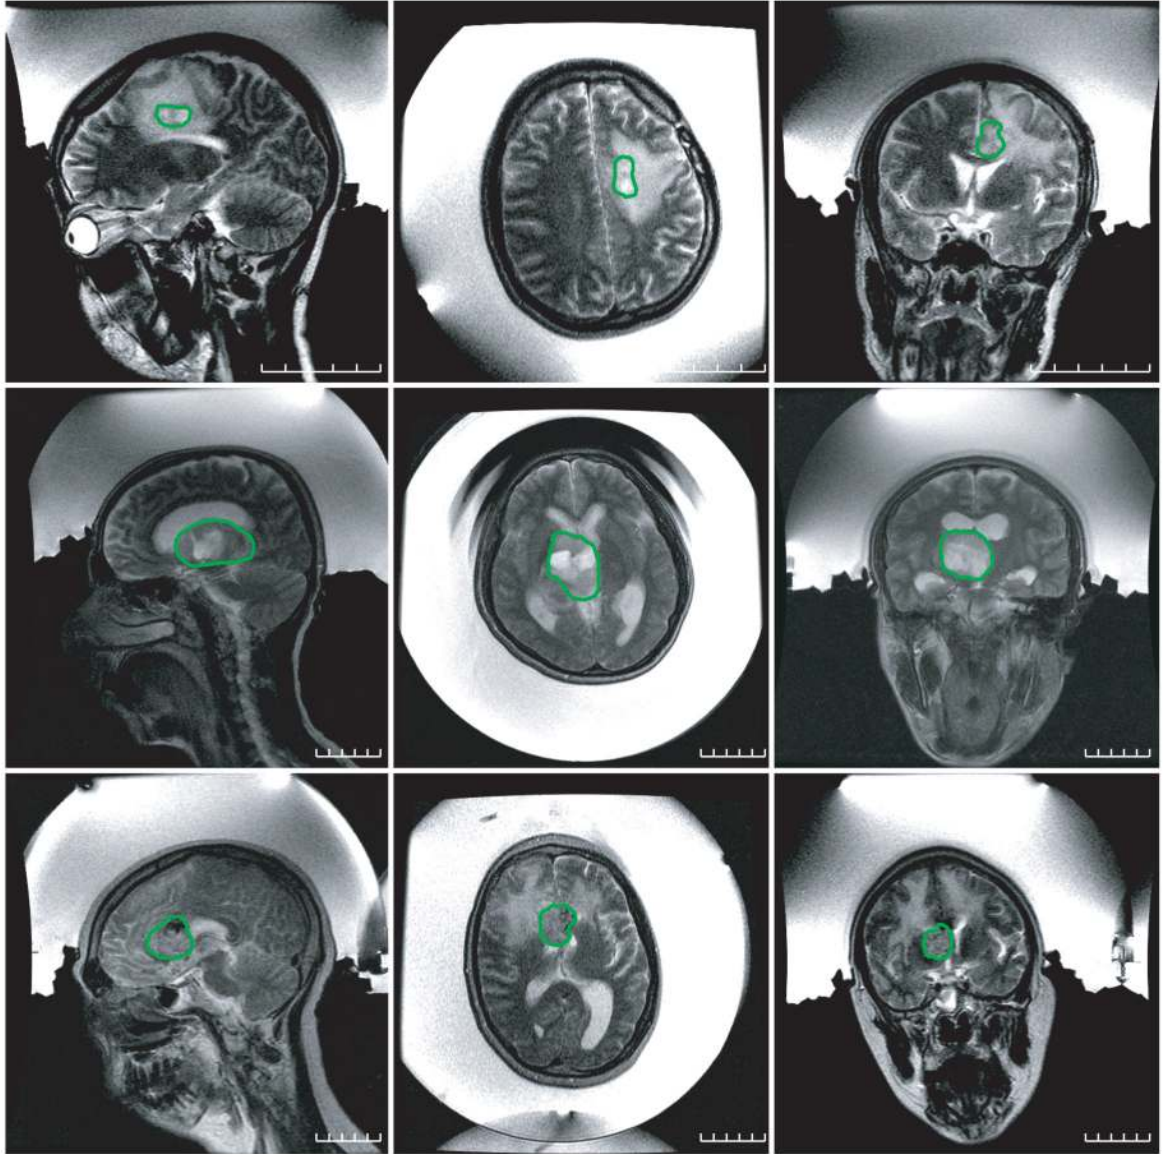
T2-weighted FSE images of the patients within the TcMRgFUS device. The outlines approximately delineate the boundaries of the targeted tumors. The space between the patients' shaved heads and the hemispherical transducer was filled with chilled water that was continuously degassed and circulated before and between sonications. (Top: patient #1, middle: patient #2, right: patient #3; left: sagittal images, center: axial images, right: coronal images)
